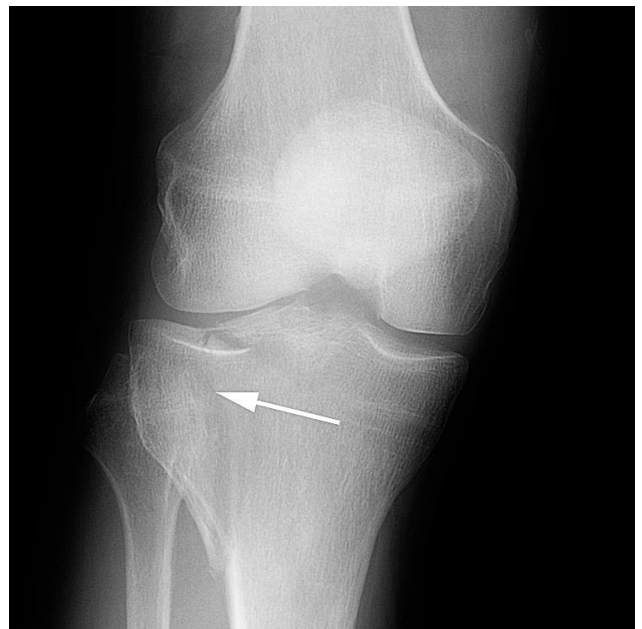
Tibial fracture in a 66 year old man with pain following trauma. AP plain film exam shows a parasagittal fracture through the lateral tibial plateau (arrow).
